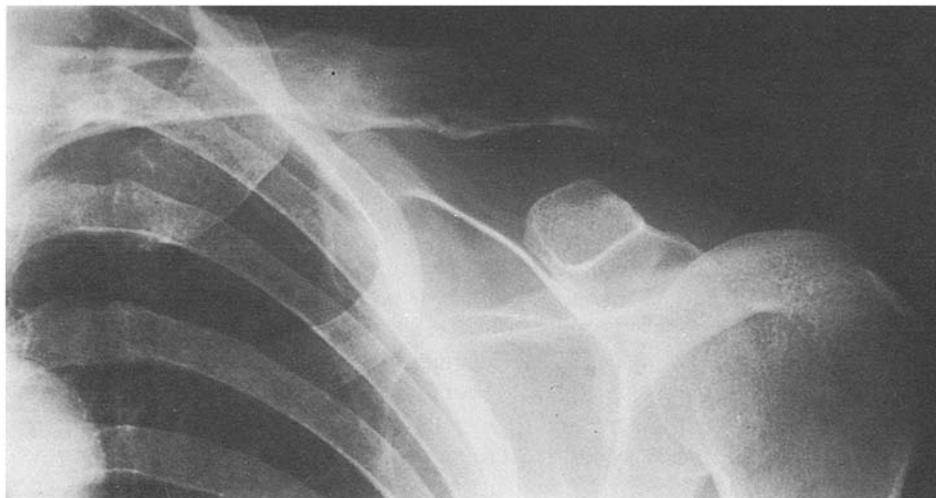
X-ray of the left clavicle in case no. 16 before chemotherapy
